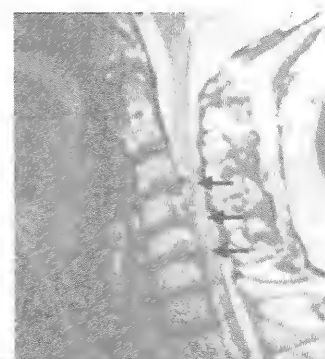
MRI showing cord compression by prolapsed discs at 3 levels (arrows).
